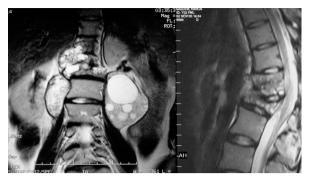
b. preoperative MRI showing multiple giant paravertebral abscesses at the level of T11-12 and L1 vertebrae.
